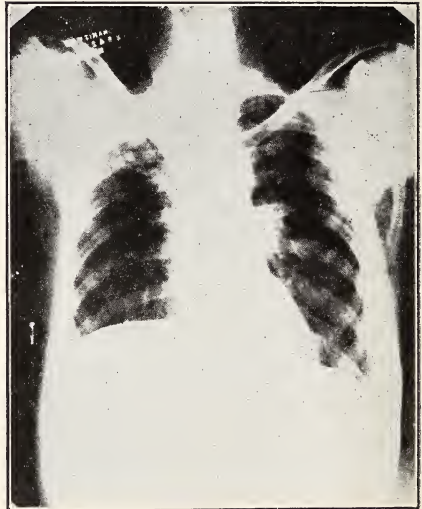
Anterior posterior roentgenogram of chest and diaphragm in amebic abscess of the liver. Note characteristic elevation of right leaf of diaphragm and obliteration of cardiophrenic angle.
